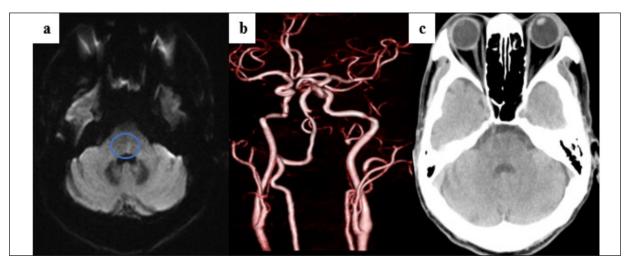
The second case. a, DWI shows a new medullary infarction (blue circle). b, MRA shows no LVO in the posterior circulation. c, The postoperative CT scan did not indicate intracranial hemorrhage.
